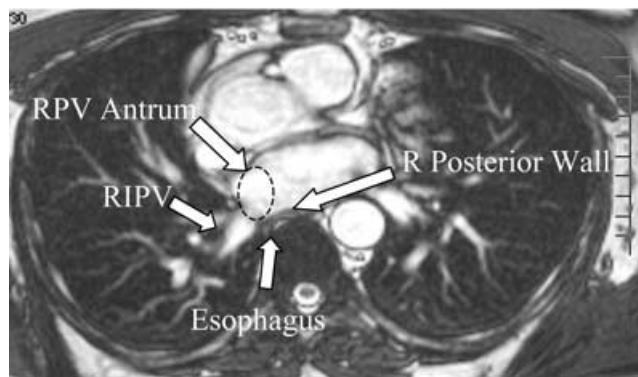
Esophagus at right pulmonary vein in the same patient by ICE and MRI. A: ICE image of the LA with a lasso catheter positioned at the antrum of the right pulmonary venous system. In this view, the esophagus is visible near the right inferior PV (RIPV), RPV antrum, and right posterior LA wall. B: Standard axial MR angiographic imaging.
